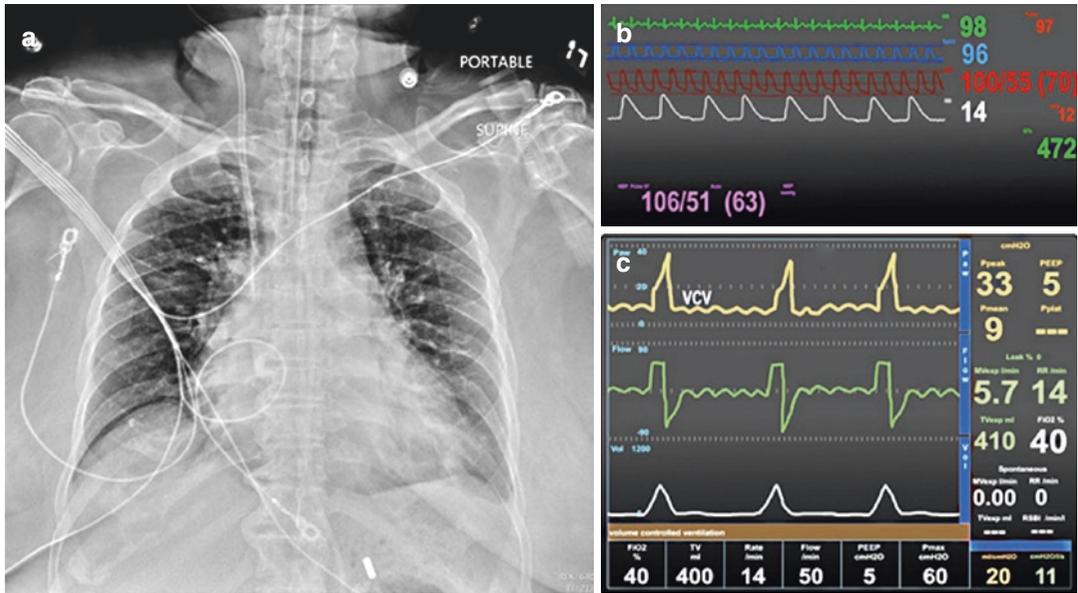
(a) Chest x-ray of index patient on admission day 3. (b) Telemetry monitor showing the patient’s vital signs on admission day 3. (c) Mechanical ventilator parameters of the index patient on admission day 3
